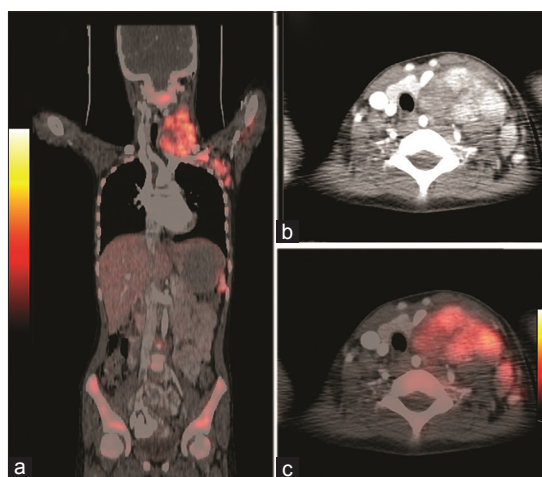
Post-chemotherapy Ga-68 DOTATATE PET/CT coronal image (b) shows decrease in tracer uptake in the soft-tissue mass in the neck (SUVmax 5.1), cervical and axillary lymph nodes and in the skeleton without significant change in the size of the lesions. Transaxial CT, (b) and fused PET/CT (c) images show a significant decrease in tracer avidity (SUVmax 5.1) compared with pre-therapy scan
